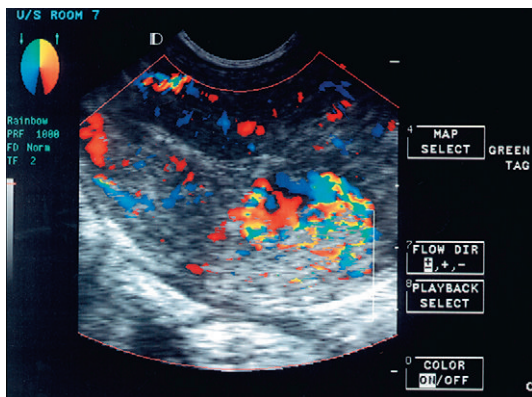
Colour flow Doppler of flow in trophoblastic tumour.
